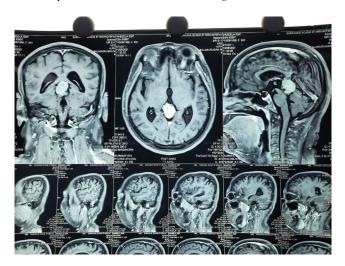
MRI brain showing pineal region tumor.
